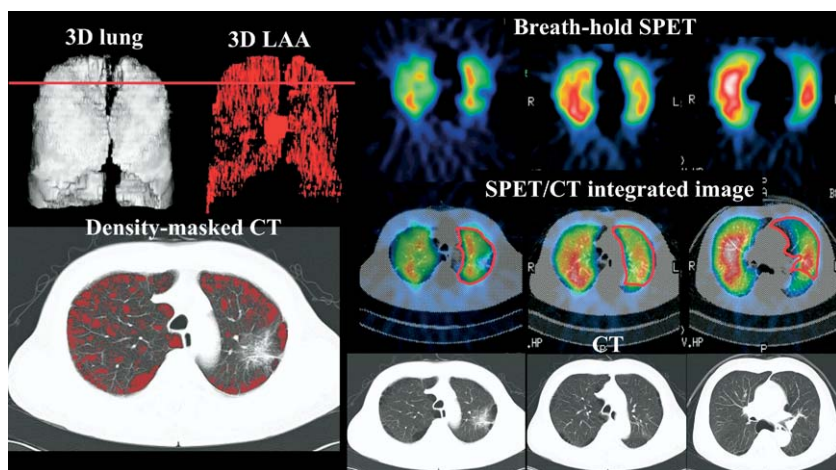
Three-dimensional (3D) lung volume and low-attenuation area (LAA) images (left, top), density-masked computed tomographic (CT) image at the lung plane with primary lung cancer (top left, red line; bottom left), and image set of transaxial breath-hold perfusion single-photon emission CT (SPET), SPET/CT integrated, and CT images (right) in a 68-year-old man with adenocarcinoma in left upper lobe. The 3D LAA and density-masked CT images clearly show that this patient has bullous emphysema, with an emphysema index of 15.2% and an FEV₁ of 0.97 L. The predicted residual FEV₁ values after left upper lobectomy on the basis of lung segment counting and integrated images were 0.71 L and 0.62 L, respectively. Based on the marginal FEV₁ predicted on the basis of integrated images, this patient was recommended to undergo resection of the left upper segment (S¹⁺² and S³). By preserving the left lingular segment, the residual FEV₁ values predicted by means of lung segment counting and integrated images were 0.82 L and 0.74 L, respectively. The predicted FEV₁ determined on the basis of integrated images correlated better with the postoperative actual FEV₁ of 0.71 L than the predicted value provided by means of lung segment counting.
